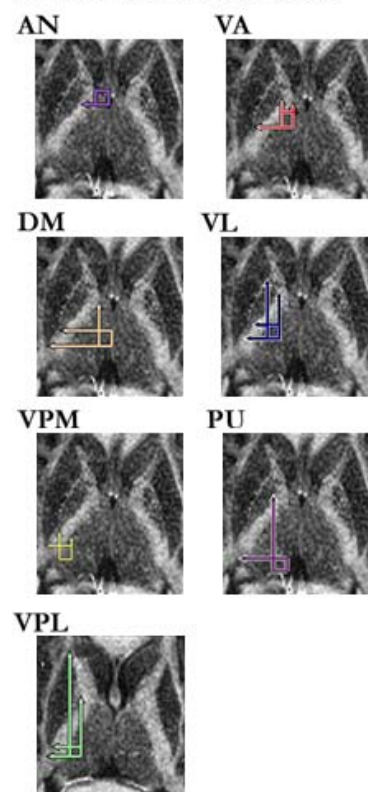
Figure e2. Methods for thalamic segmentation. Boundaries for identification of thalamic nuclei using the color-coded FA image, the T1-weighted SPGR, the primary eigenvector image, the T2-weighted FSE, and the black and white FA maps. 1B. Seed region placement and rules for placement for the anterior nucleus (AN, purple), ventral anterior nucleus (VA, red), dorsal-medial nucleus (DM, orange), ventral lateral nucleus (VL, blue), ventral posterior medial nucleus (VPM, yellow), pulvinar (PU, pink), and the ventral posterior lateral nucleus (VPL, green). 1C. Fiber tracts identified by these seed regions for a single subject.
